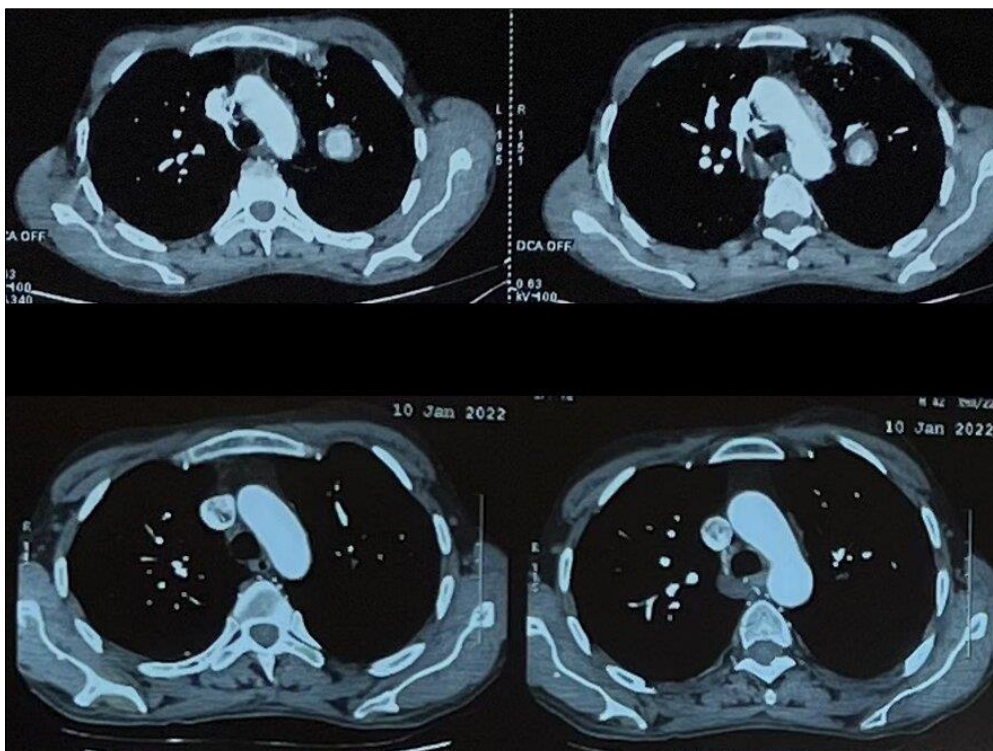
Follow-up CTA revealing complete resolution of vascular abnormalities
